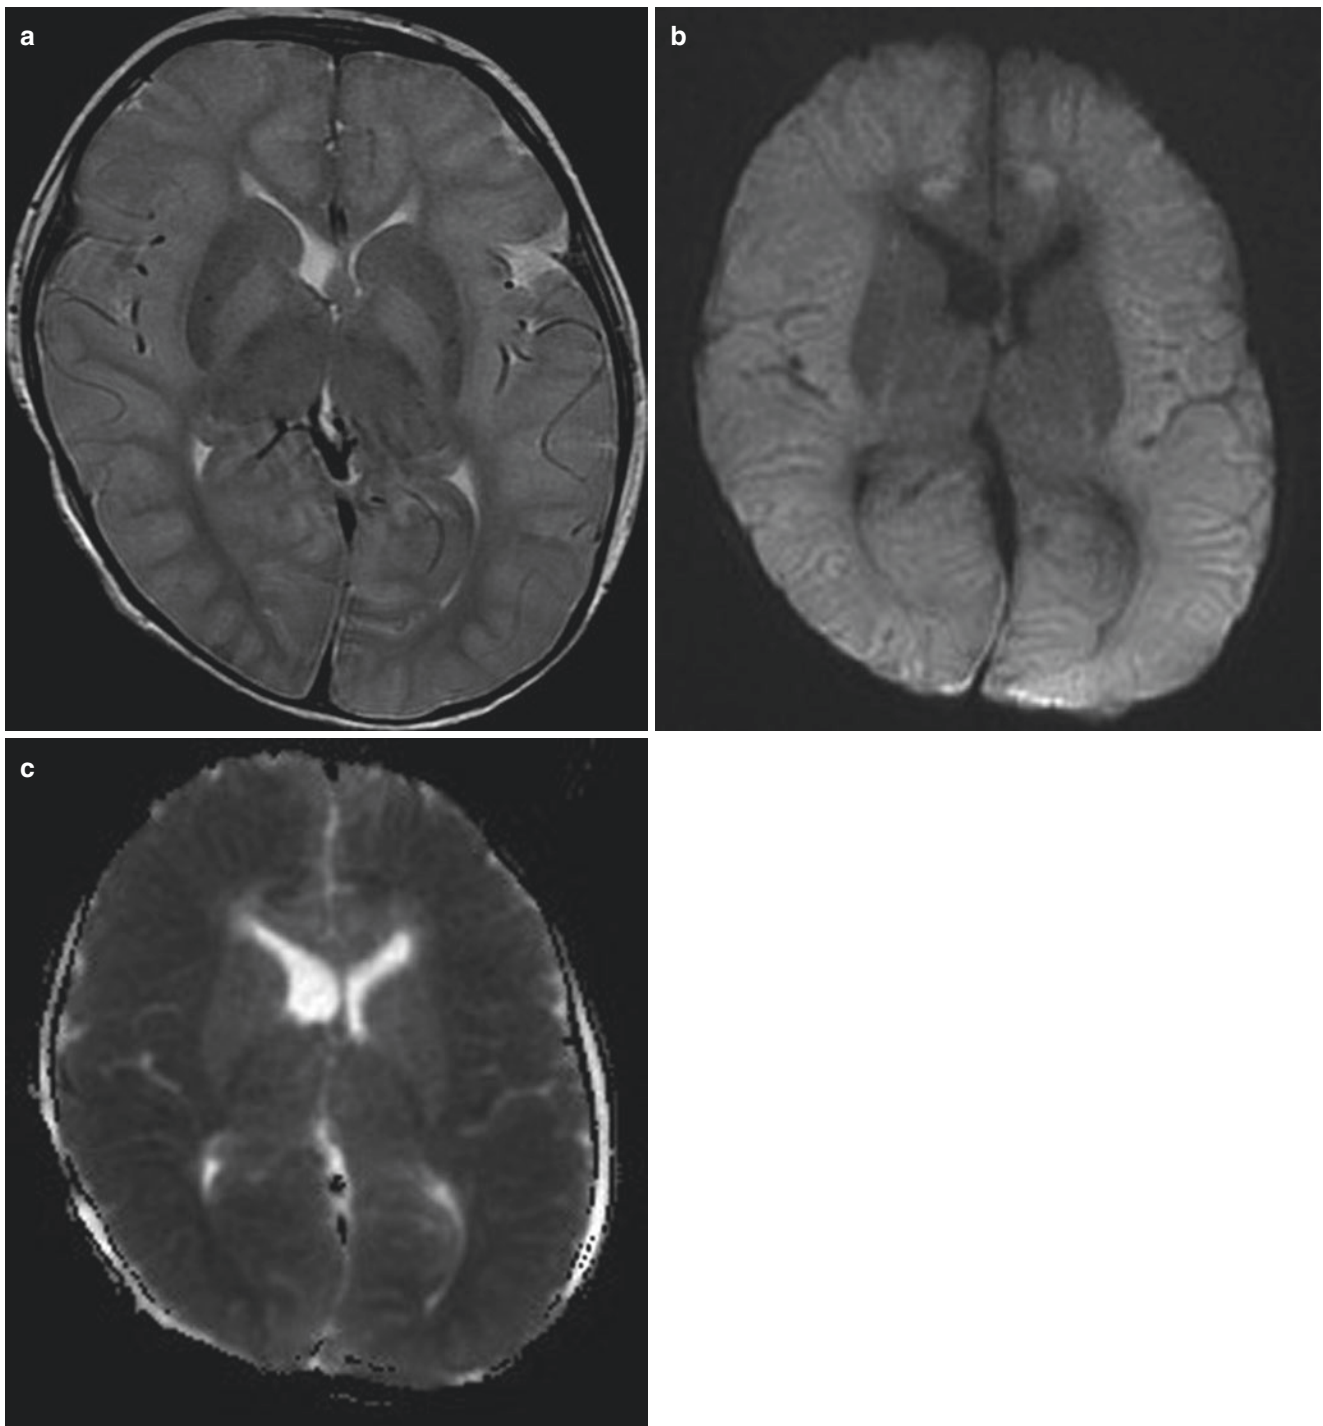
Axial T2 MRI (a), diffusion weighted (b) and ADC (c), of the brain at the level of the frontal lobe reveals bilateral cerebral cortex and basal ganglia T2 high signal with restricted diffusion in keeping with cerebral oedema
